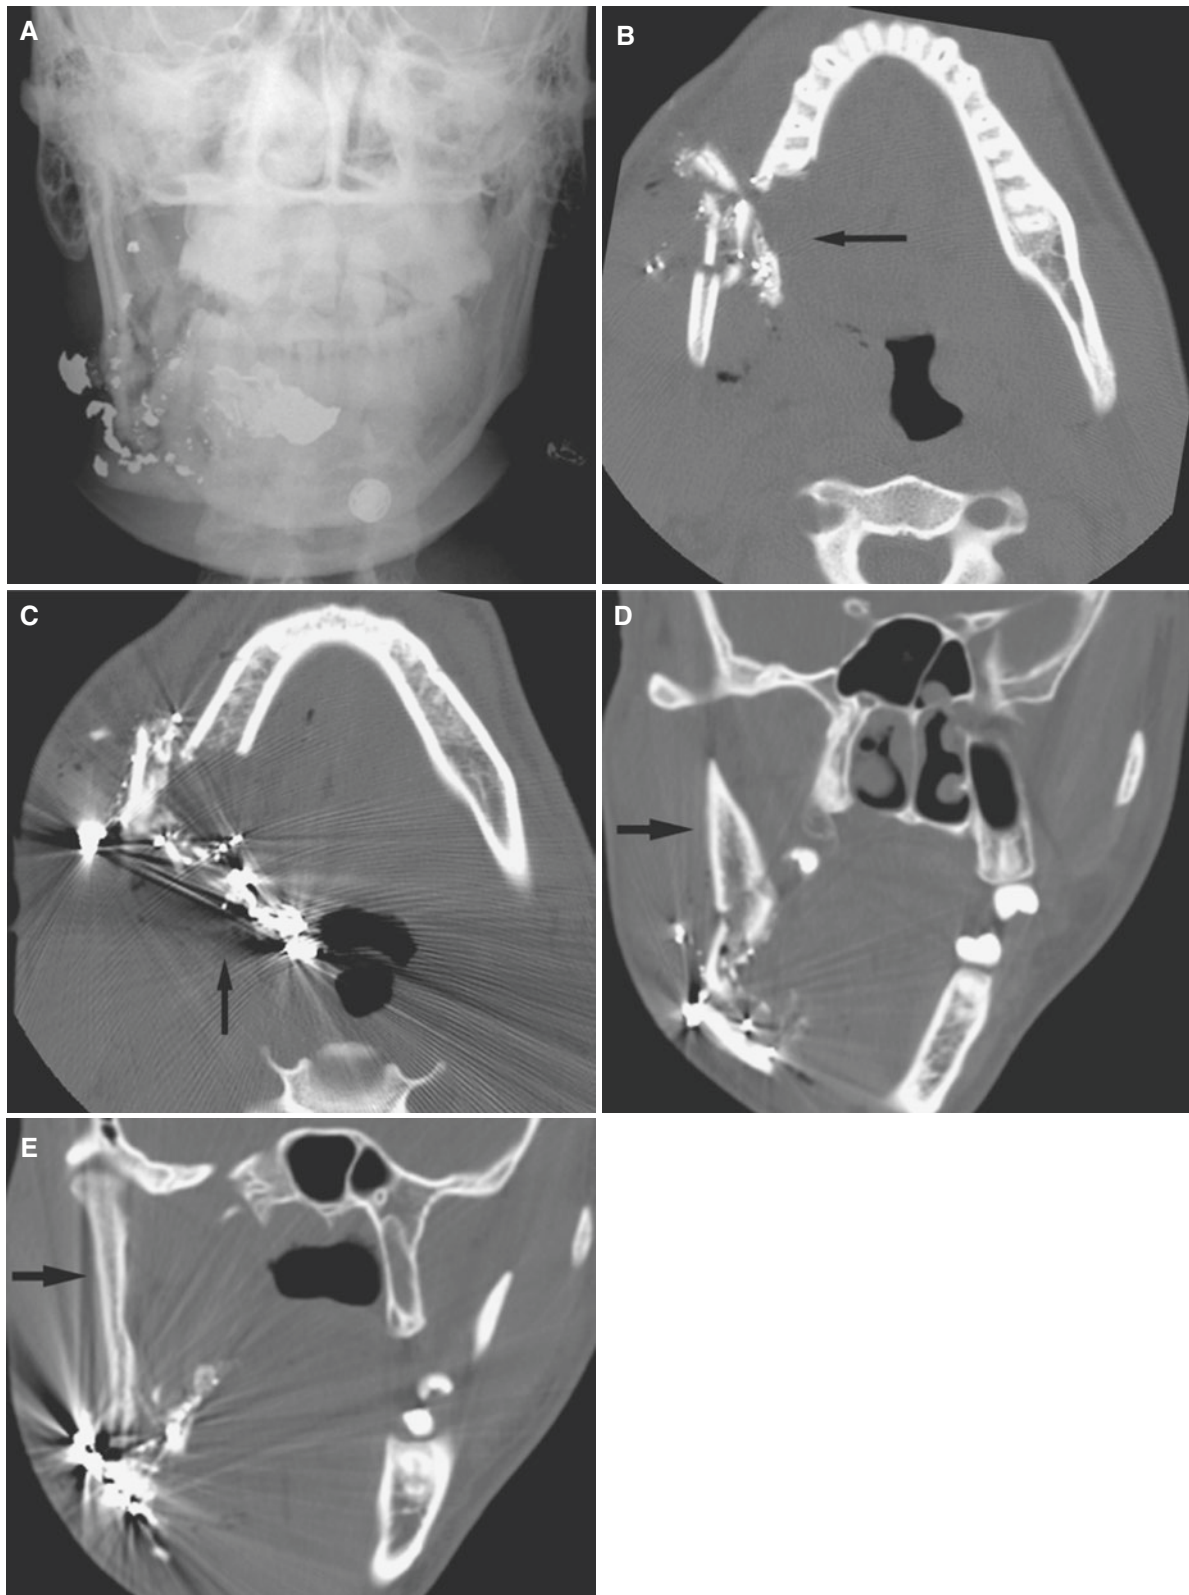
Mandibular body fracture, comminuted; 17-year-old male with gunshot to the face. (A) En face view shows multiple bone and metallic fragments and an intratracheal tube. (B) Axial CT image of tooth-bearing area shows comminuted fracture with many bone and metallic fragments (*arrow*). (C) Axial CT image at a more caudal level
